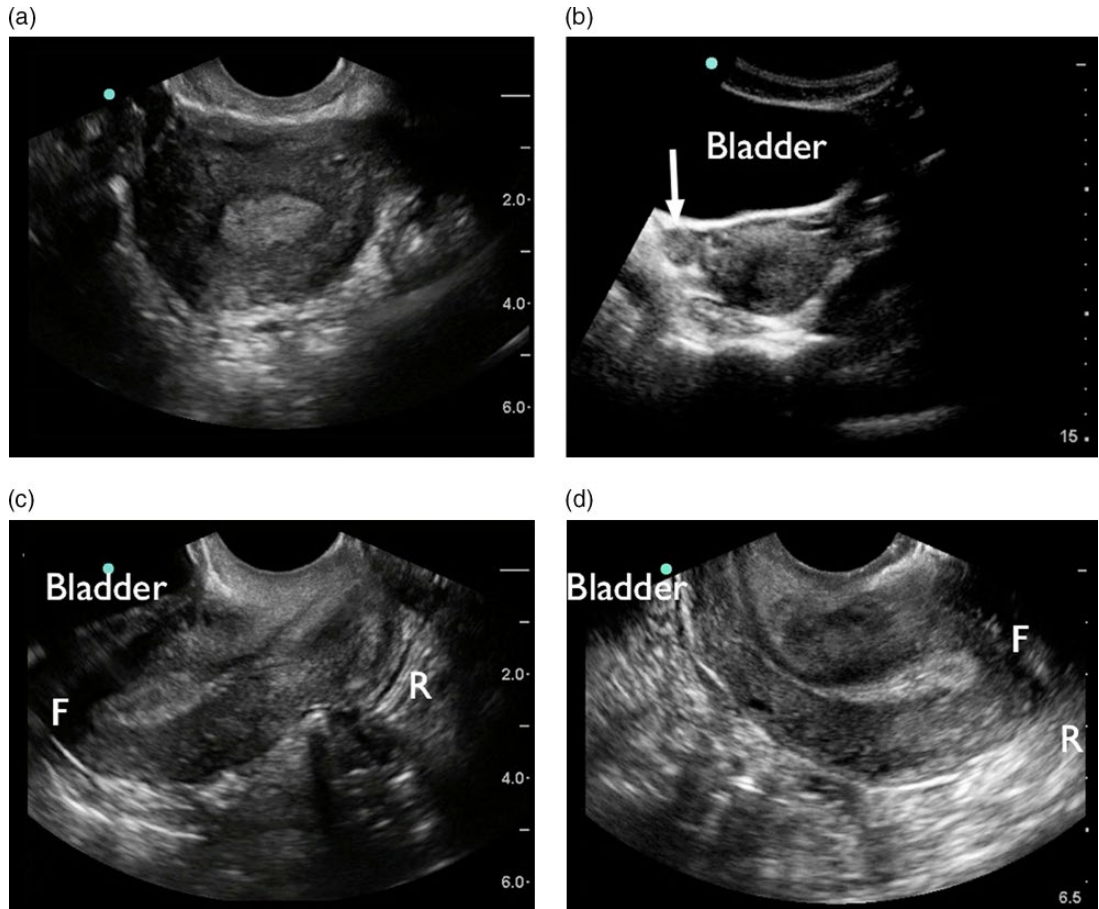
Sonographic images of the uterus. (a) Transvaginal imaging, uterus in coronal plane. The relatively hyperechoic endometrium is surrounded by a uniformly thick myometrium. (b) Transabdominal imaging with uterus in transverse plane. The right ovary (arrow) can be seen. (c) Transvaginal sagittal image of a normal anteverted uterus. The fundus (F) is anterior (towards the left of the image). The distinction between endometrium and myometrium is again clear. (d) Transvaginal sagittal view of the retroverted uterus. Note that the fundus (F) is directed posteriorly (towards the right of the image). In both (c) and (d), the rectum (R) is seen on the right.
